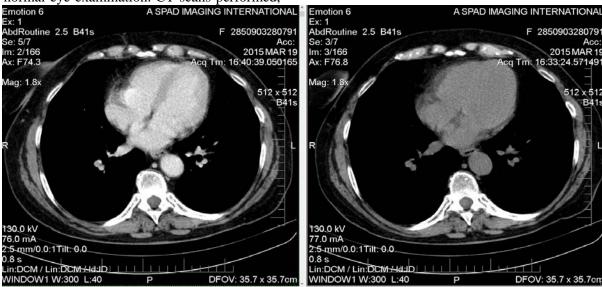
Normal CT scan 4 months after completion of therapy
